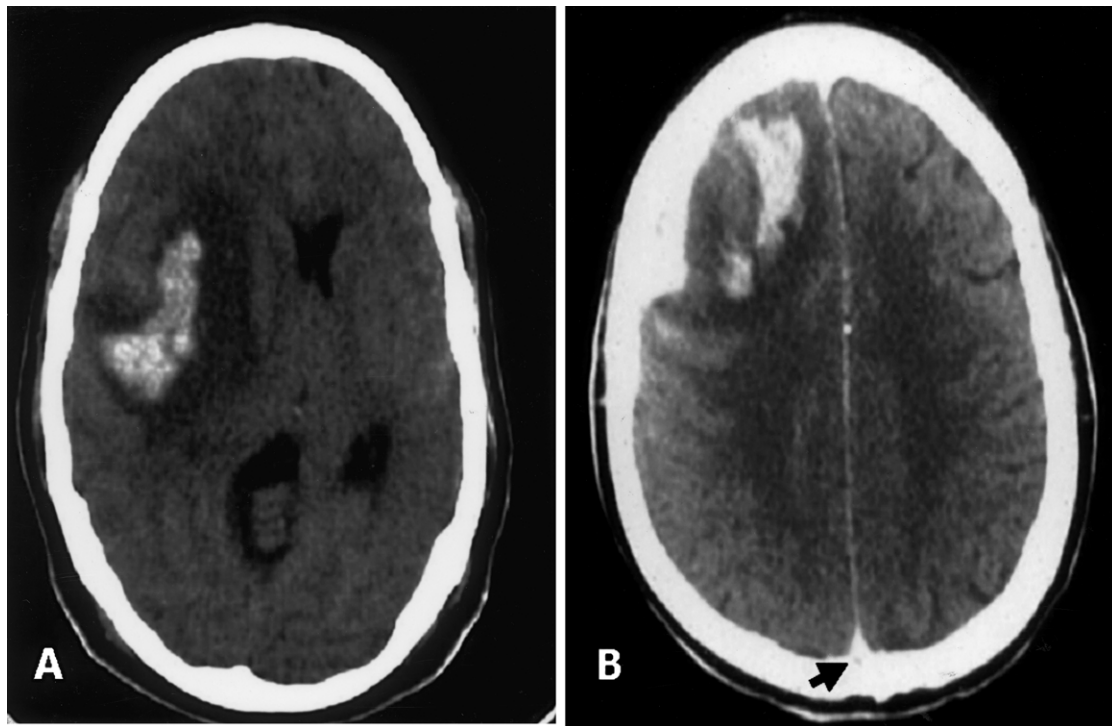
Non-enhanced CT scan of the brain of patient 1 (Panel A) showing a large right temporoparietal haemorrhagic infarct with surrounding cerebral oedema, midline shift and brain stem compression. Contrast enhanced CT scan (brain) of patient 2 (Panel B) showing a large area of hemorrhagic infarction in the right frontoparietal cortex with surrounding oedema. Absence of contrast is seen as a hypodense area in the posterior aspect of the superior sagittal sinus—the 'empty delta' sign (arrow).
